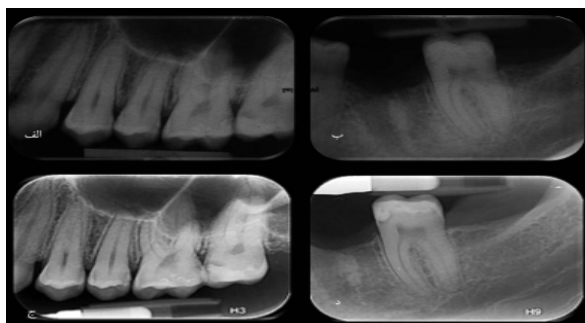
a & b: Radiographs at 12-month follow up, c: Radiographs at 30-month follow up
